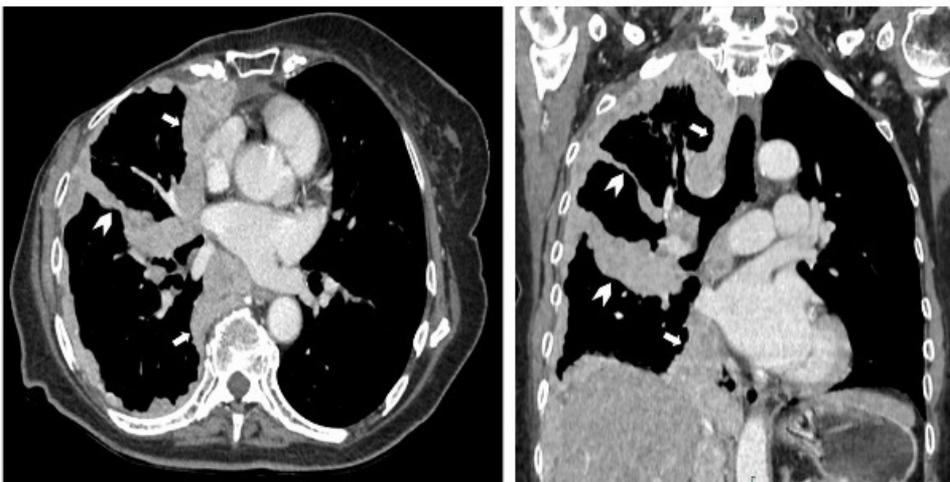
CT scan of a patient diagnosed with right breast cancer and post-right mastectomy. Axial and coronal CT scan shows circumferential pleural thickening at right hemithorax. Involvement of mediastinal pleura (arrow) and interlobar fissure (arrow head) are also demonstrated.
